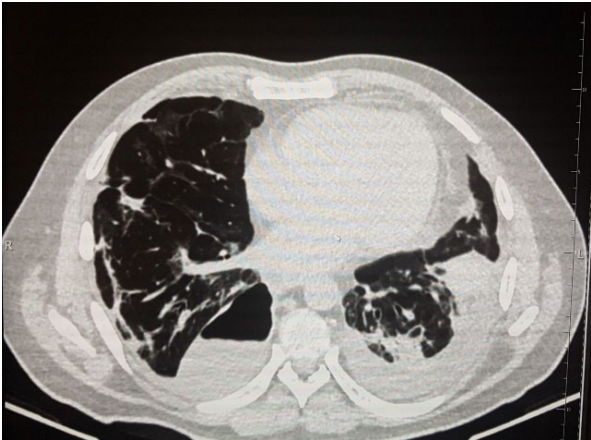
Computed tomography – November 16, 2020 – excess fluid in pleural cavities R-3.8 cm, L 2.6 cm, both cavities contain air constituting a single fluid/gas layer
